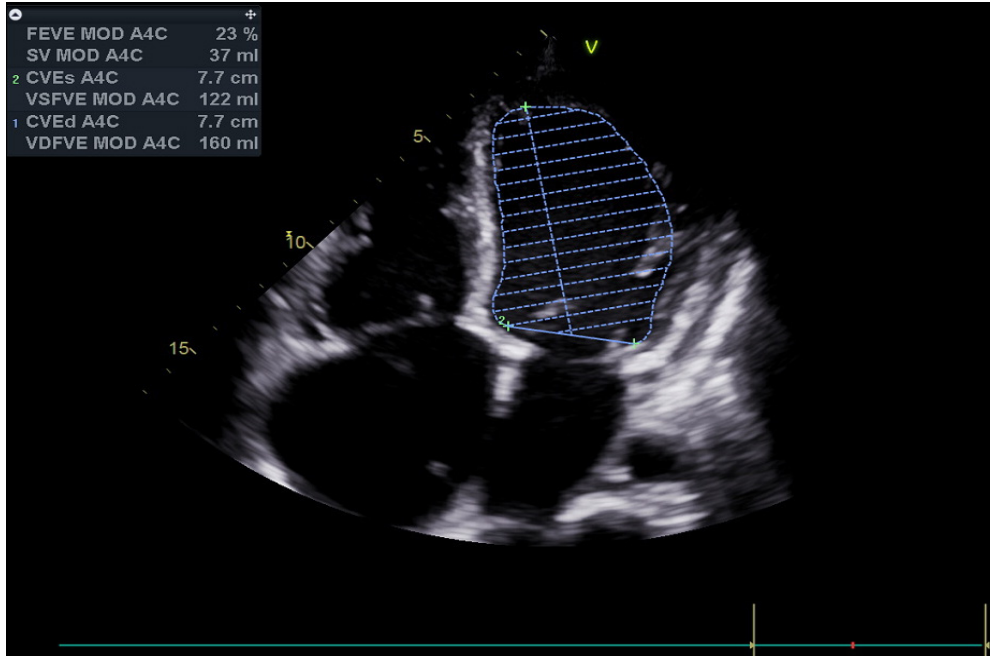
Echocardiogram: Ejection Fraction Measurement (Simpson method), Apical window Four Chamber. Ventricular ejection fraction: 23%
